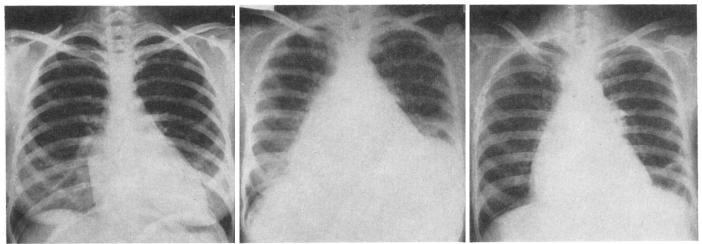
Case 2. Chest radiograph on first admission, showing heart size and configuration before propranolol.
